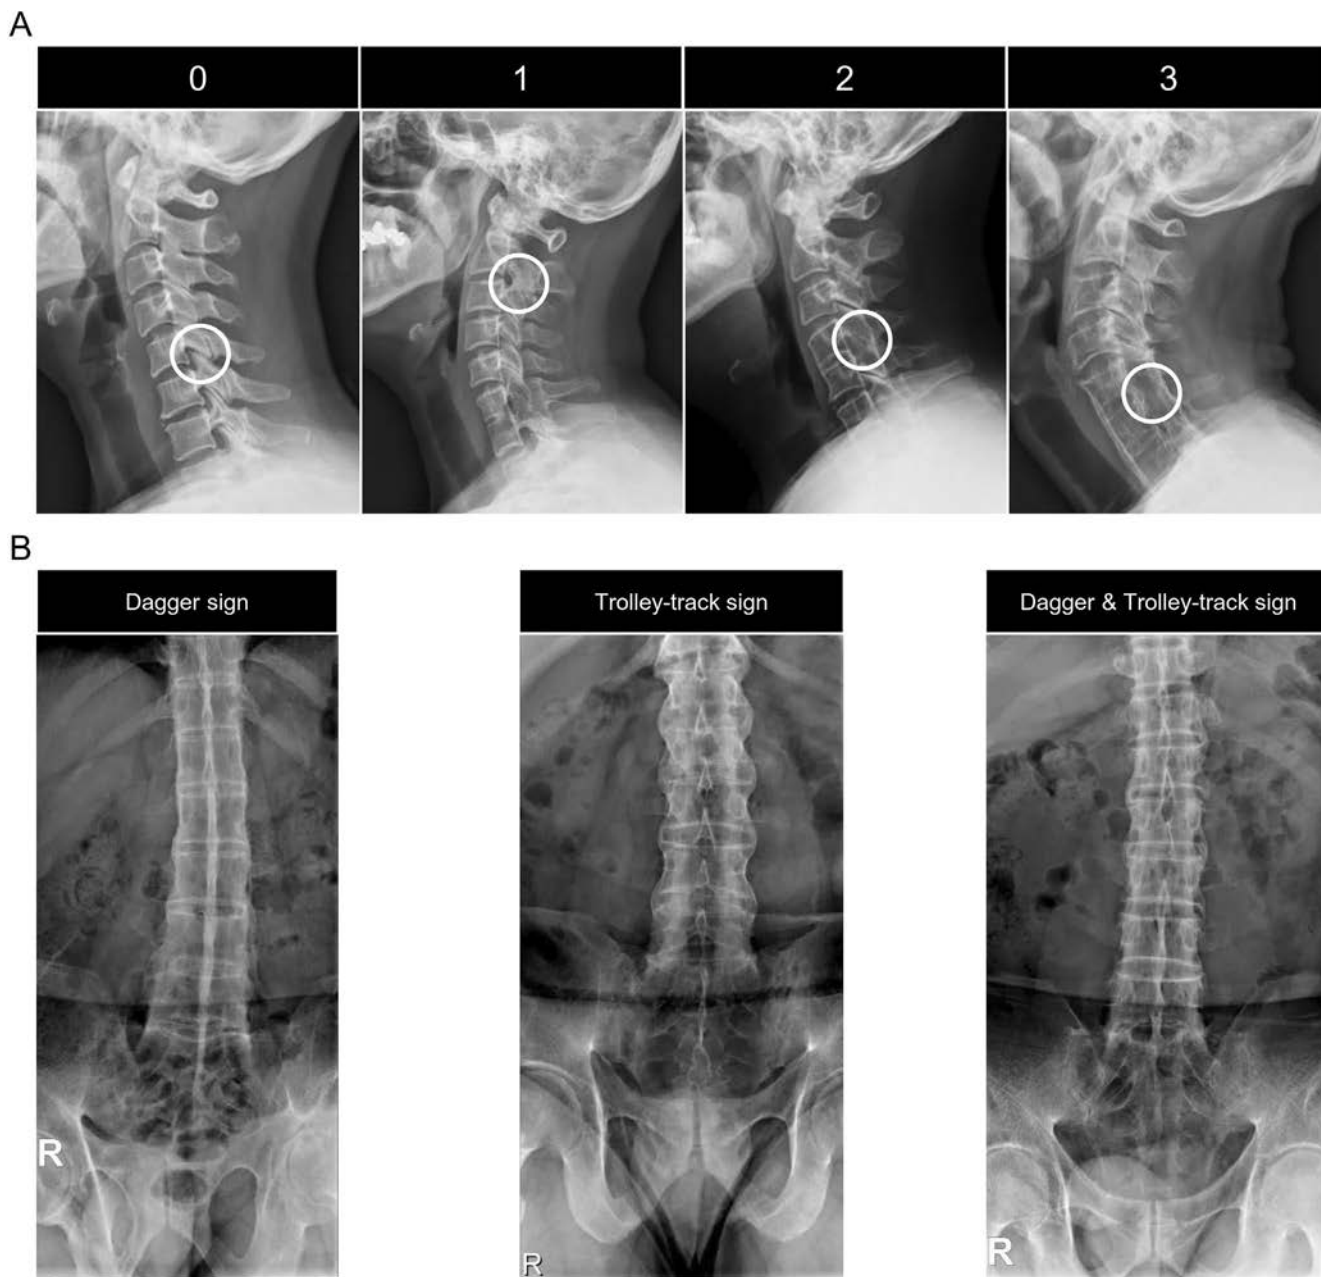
Examples of radiographic findings. (A) Scoring examples according to De Vlam method, 0: Normal; 1: Decreased joint space; 2: Partial obliteration of the space; 3: Complete obliteration of the space or ankylosis. (B) Dagger sign and Trolley-track sign.
